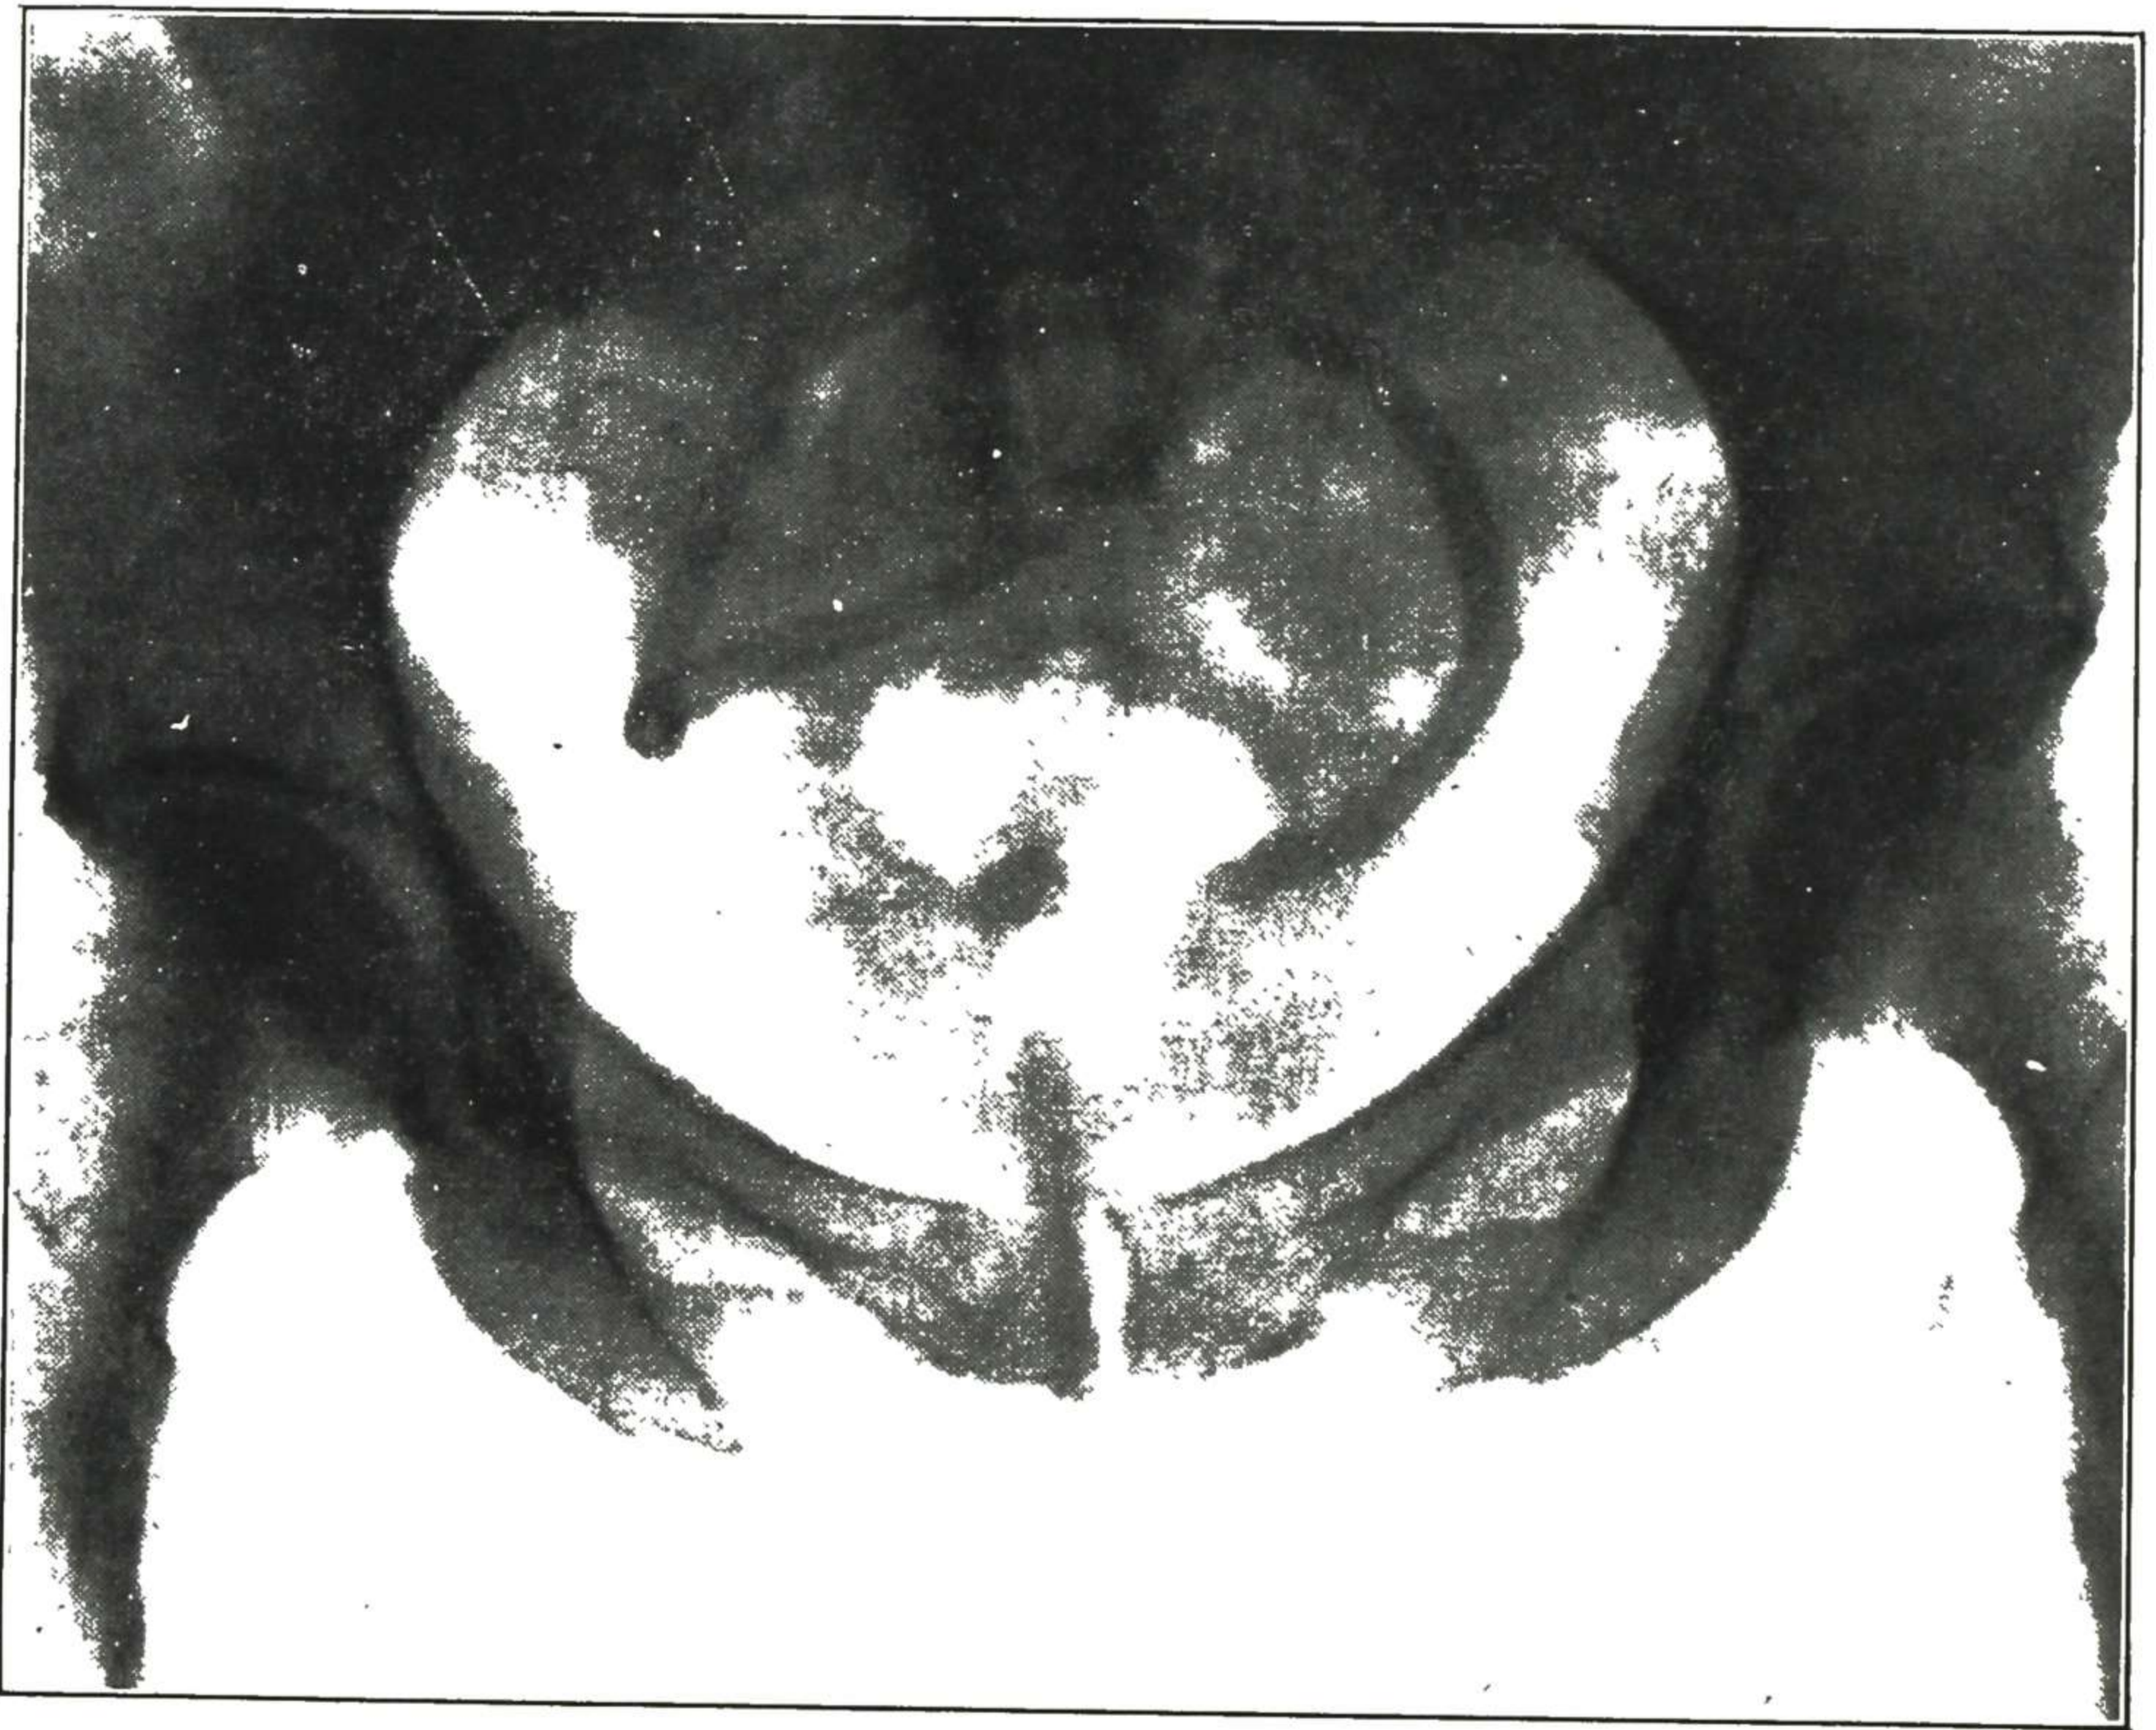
X-ray film showing a catheter in the peritoneal cavity. It had been there since an abortion twenty-six years before. (Hill—*J. Missouri M. A.*)
